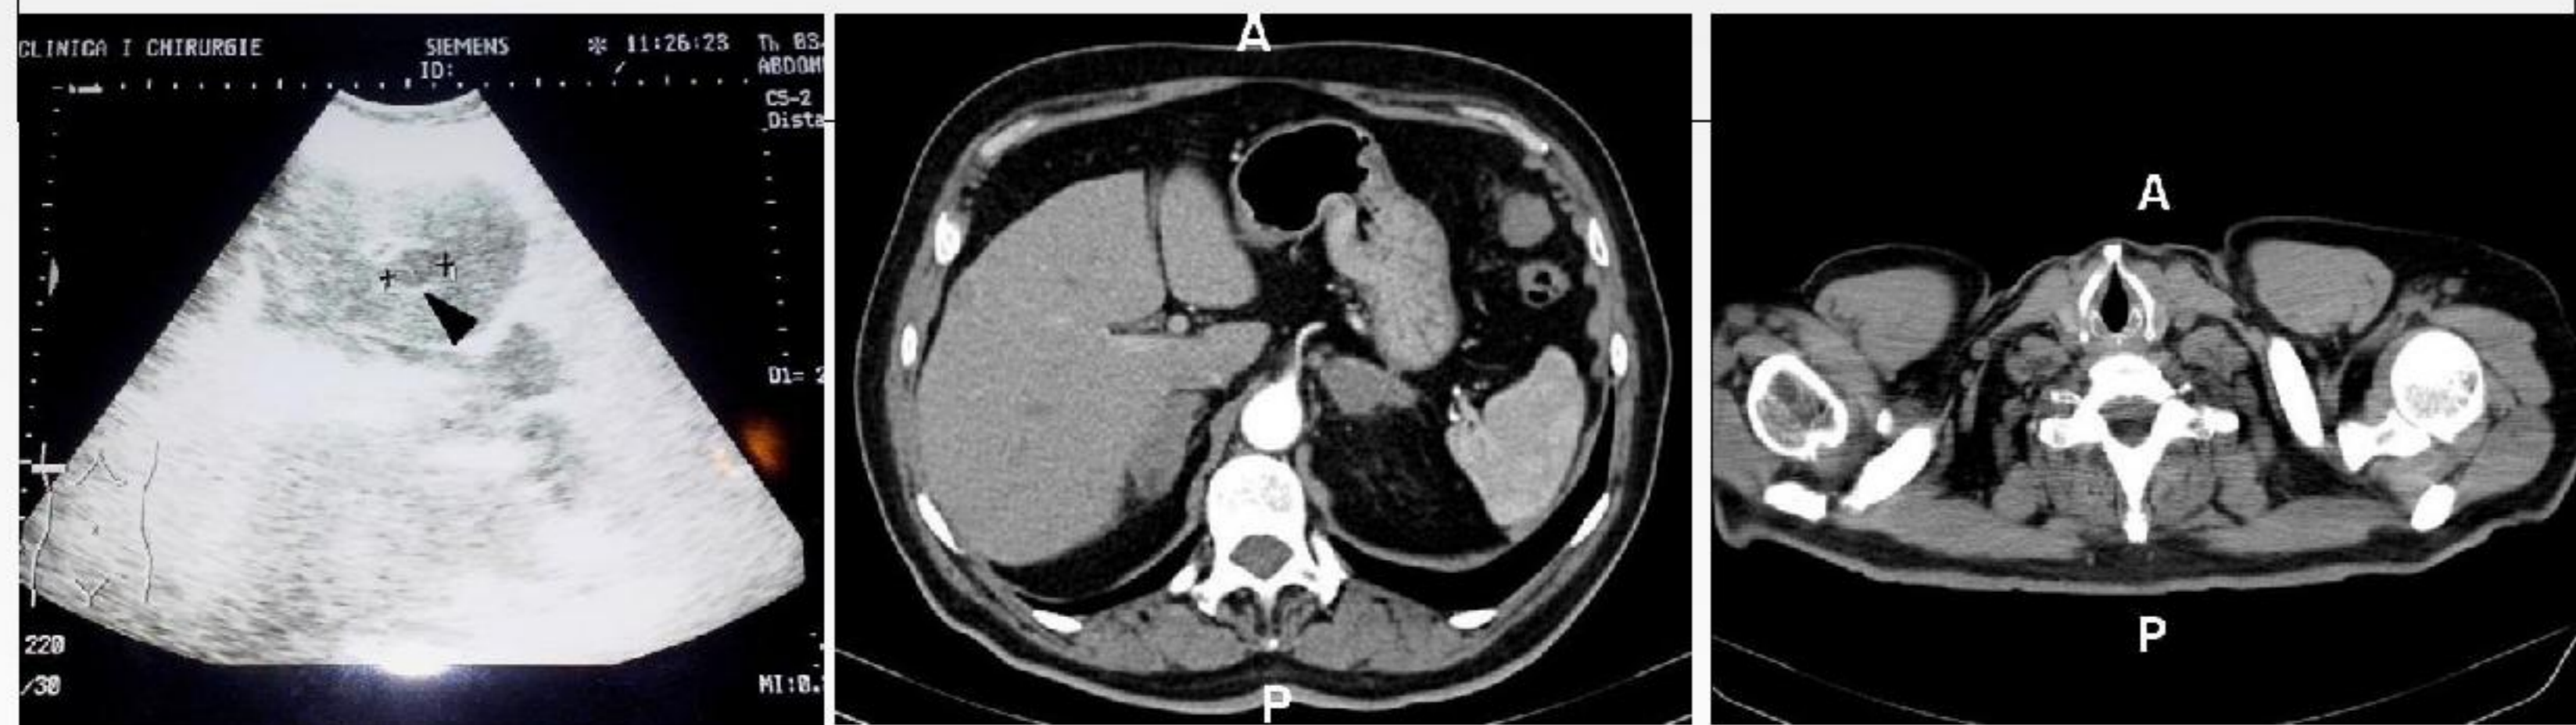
Abdominal ultrasound
